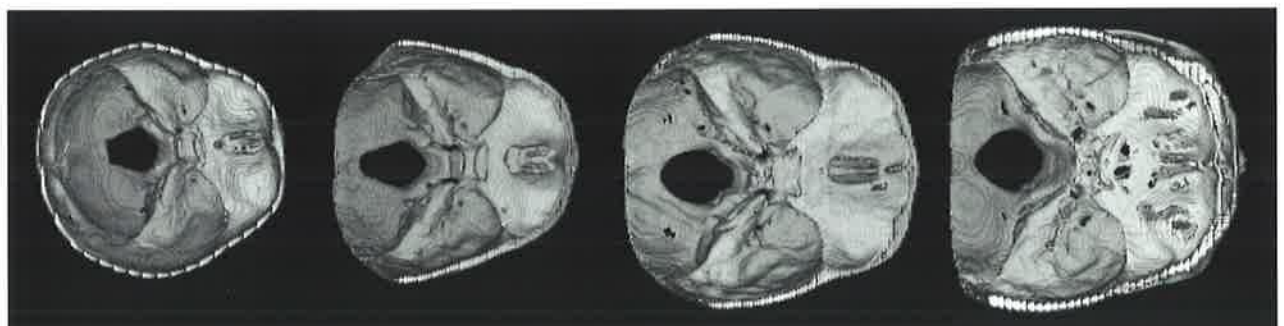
3D CT reconstructions of the cranial base for the skulls shown in Figure 3.13.
